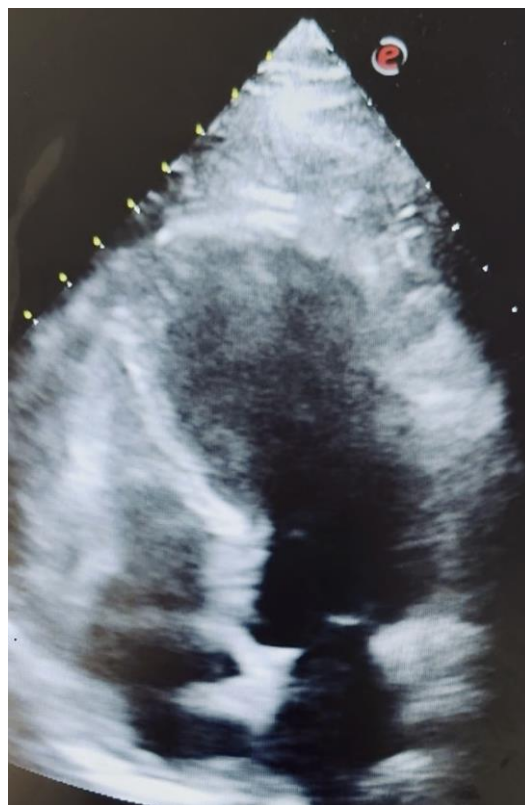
Representative apical four-chamber echocardiographic image recorded during hemodynamic deterioration. The dynamic bedside examination showed apical ballooning, mid-apical akinesia, basal hyperkinesia, and severe left ventricular systolic dysfunction, with an estimated LVEF of approximately 25%. Wall motion cannot be fully assessed from a single still image
